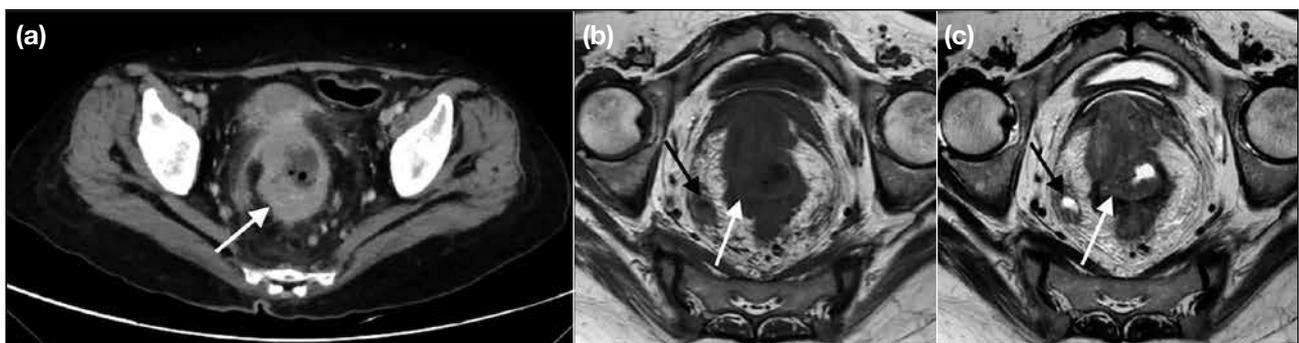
Rectal adenocarcinoma in a 69-year-old woman. (a) Contrast-enhanced computed tomography showing eccentric mural thickening with irregular margin involving the mid rectum (white arrow). (b) T1-weighted and (c) T2-weighted magnetic resonance imaging showing an irregular eccentric mural mass (white arrow) that is T1 isointense and mildly T2 hyperintense relative to muscle. Perirectal lymphadenopathy is present (black arrow).
